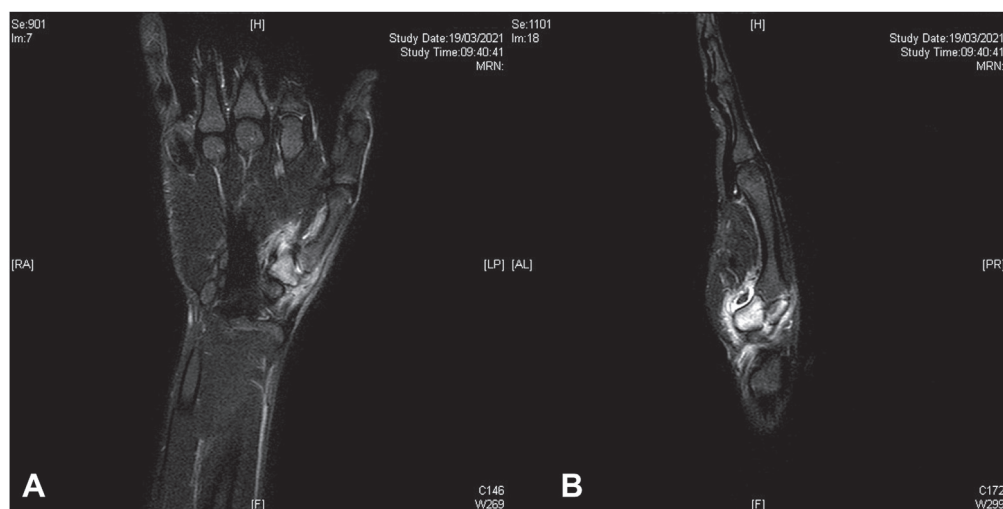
A Sagittal and B longitudinal views of the MRI examination performed before surgery. The bone aspect is better represented in the CT examination; in fact, the nidus, sclerotic area, and erosion are not visible. The bone edema and flogistic perilesional tissues are visible on the MRI scan.
